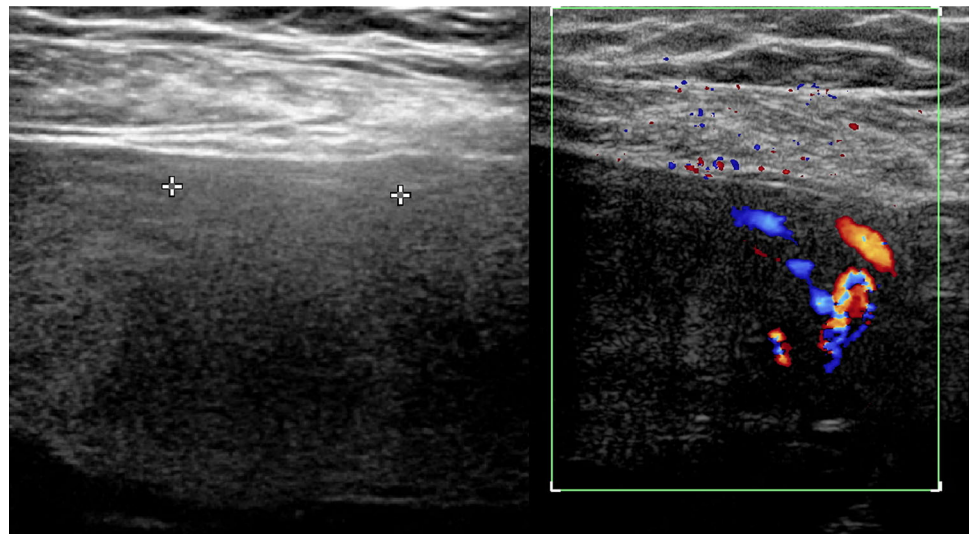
Case I: Suspicion of placenta accreta on ultrasound confirmed by fetal MRI showing dark intraplacental band on T2 imaging further improving the performance of fetal Doppler and confirming the diagnosis
